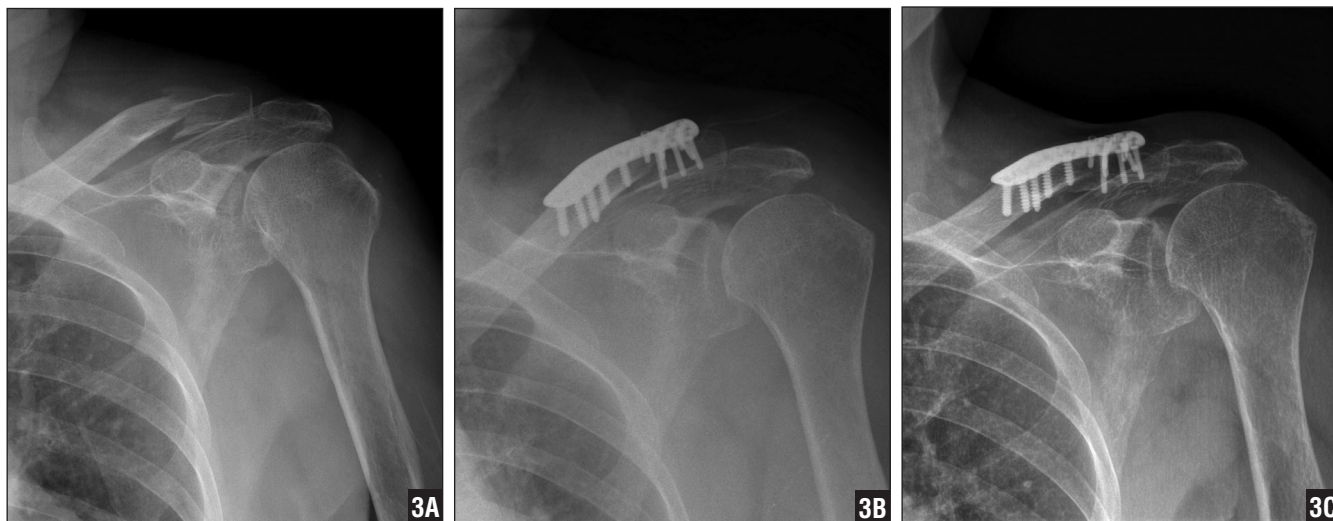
A 64-year-old woman sustained a displaced distal clavicle fracture in a simple fall. Preoperative anteroposterior radiograph showing a Neer type II fracture of the left distal clavicle with osteoporotic bone quality (A). Immediate postoperative anteroposterior radiograph showing satisfactory reduction of the fracture (B). Anteroposterior radiograph taken 16 months postoperatively showing the obliteration of fracture lines and well-maintained reduction without screw pullout (C).
